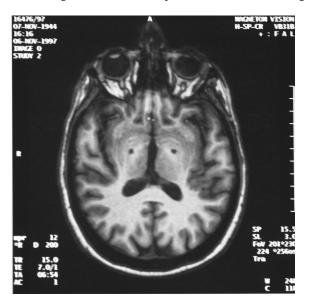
Post-operative axial MRI scan showing bilateral pallidotomies (Globus Pallidus internus) in a patient with dystonia.
